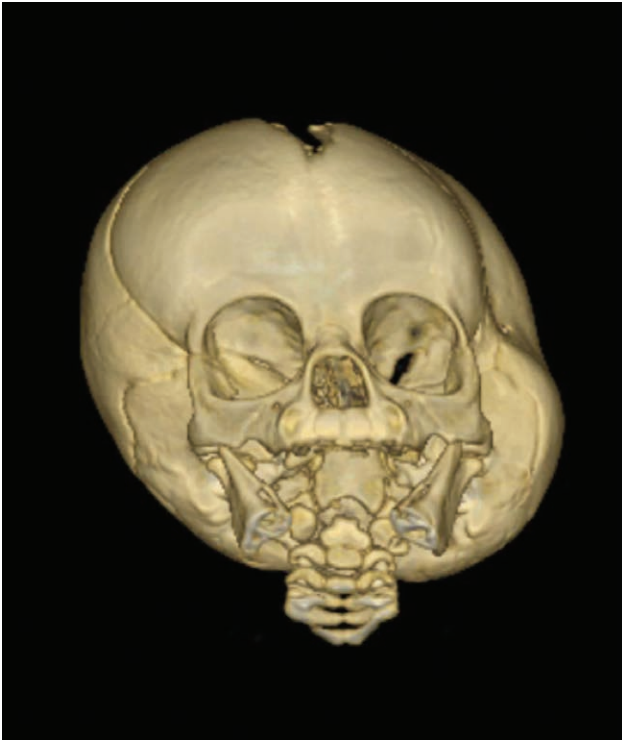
Preoperative CT scans; child aged 5 months old.
